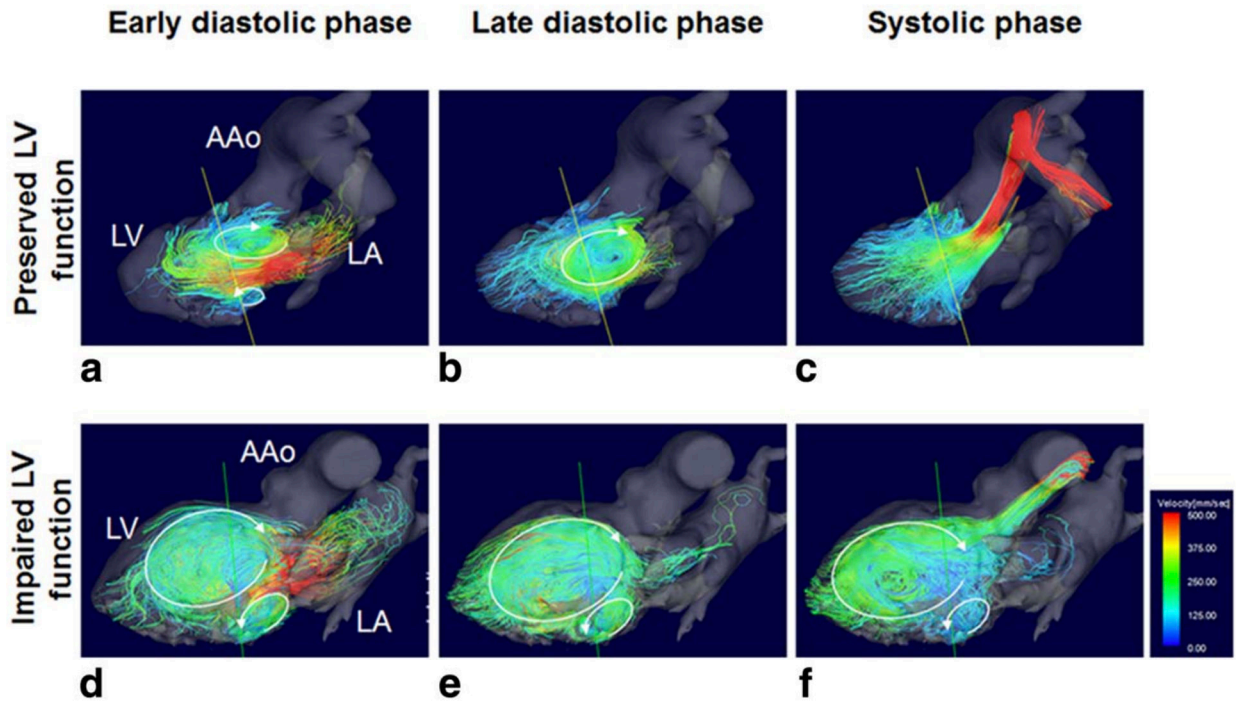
Color-rendered Streamline 4D Flow CMR Images with Intraventricular Vortex Patterns. Relative to a patient with normal left ventricular (LV) function (*upper panel*), the patient with reduced LV function (*lower panel*) has altered vortical flow (white circular arrow(s)) throughout of the cardiac cycle (early diastole, late diastole, and during systole). Note the absence of vortex formation during systole in the setting of normal LV function and persistence of vortex formation during systole in the setting of impaired LV function. From Suwa K, Saitoh T, Takehara Y, et al. Intra-left ventricular flow dynamics in patients with preserved and impaired left ventricular function: Analysis with 3D cine phase contrast MRI (4D-Flow). *J Magn Reson Imaging*. 2016;44:1493–1503.; with permission. (Figure 1 in original)
